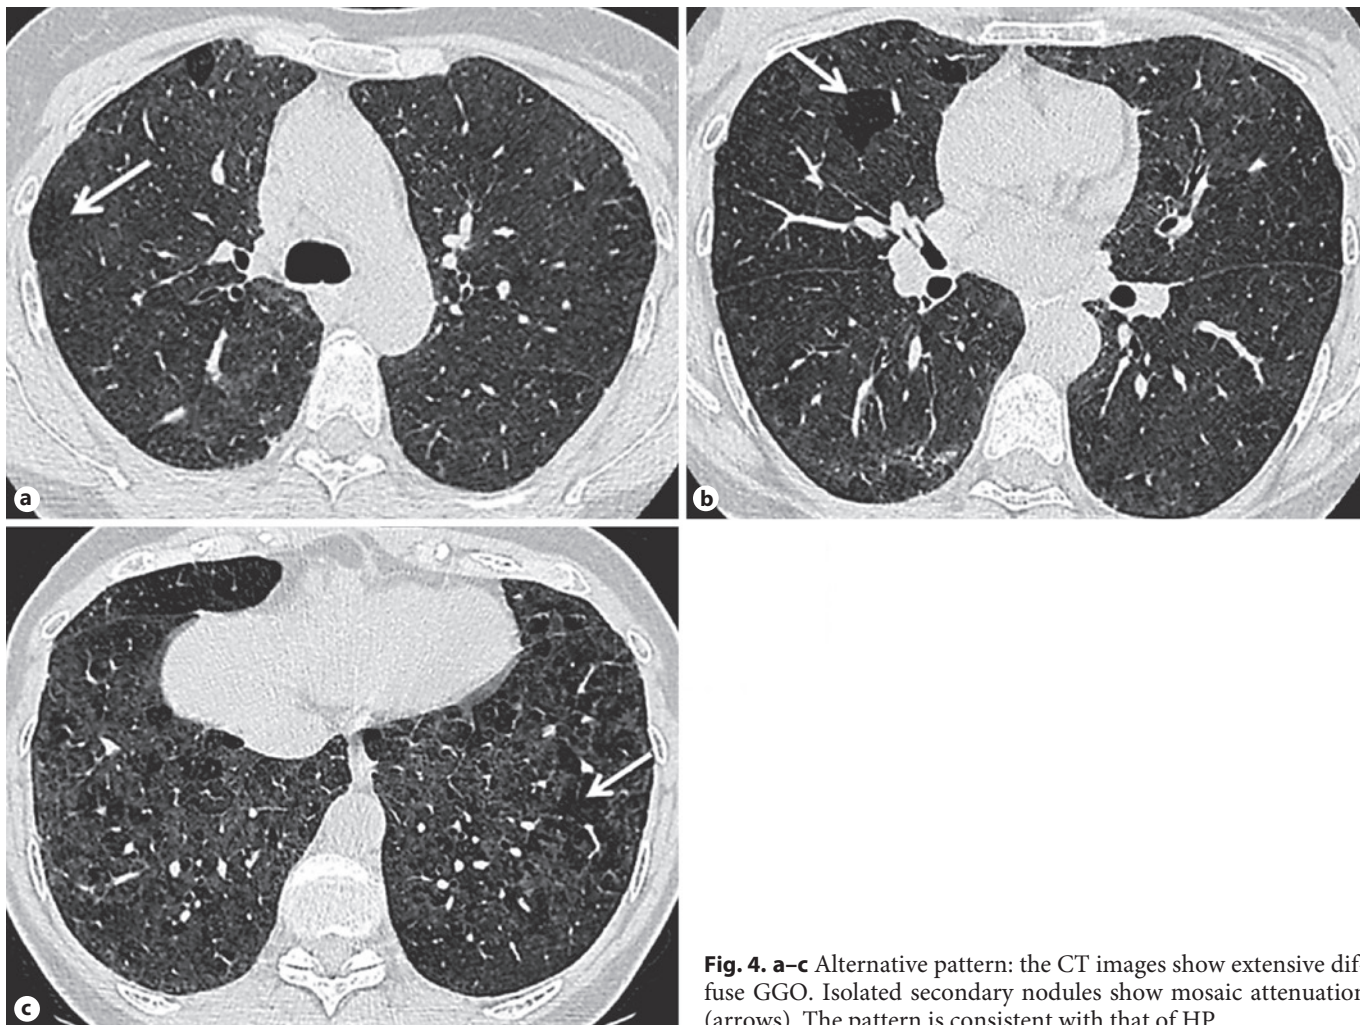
a–c Alternative pattern: the CT images show extensive diffuse GGO. Isolated secondary nodules show mosaic attenuation (arrows). The pattern is consistent with that of HP.
